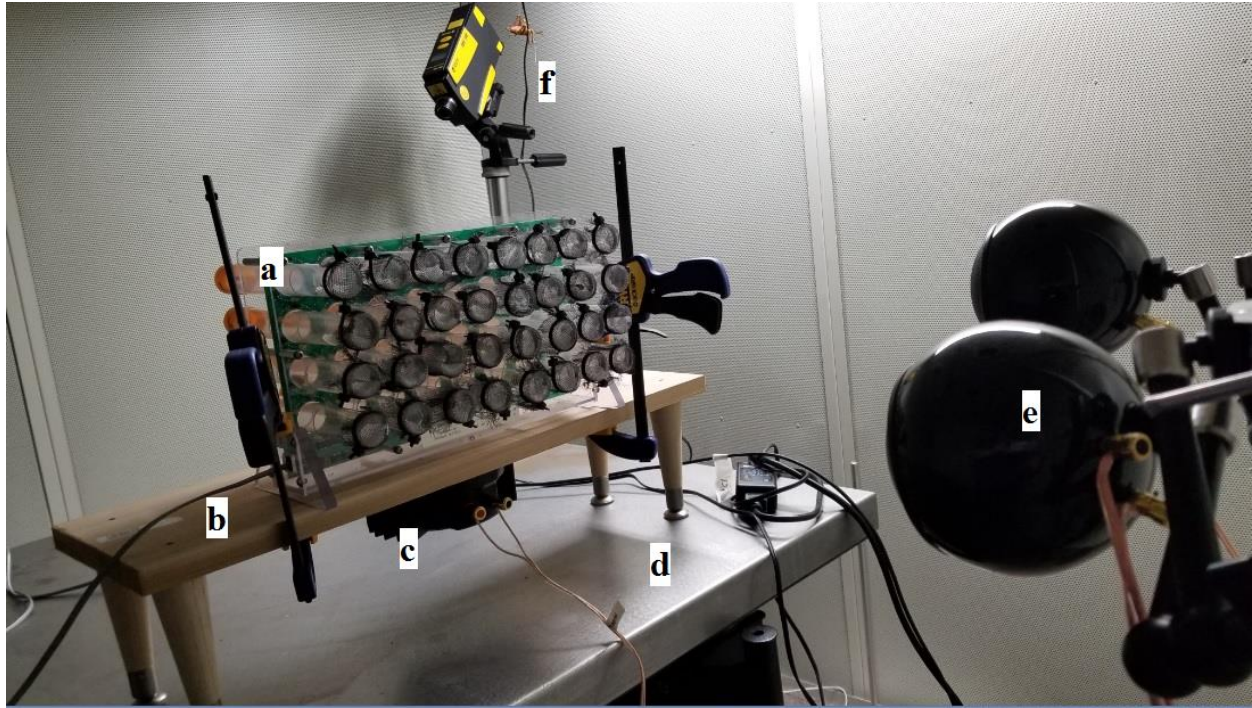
The experimental setup. The locomotor activity monitor (a) is seen with 32 tubes, each containing one cricket, with food and water on either side. One side is capped (orange plastic cap), while the other is covered with mesh screening to allow airborne noise to pass through. The monitor sits on a wooden platform (b) which contains the bass shaker underneath (c). The platform sits on a vibration isolation table (d) within the hemi-anechoic chamber. Two speakers (e) were used for airborne noise playback. A laser doppler vibrometer (f) was used to calibrate substrate vibration.
